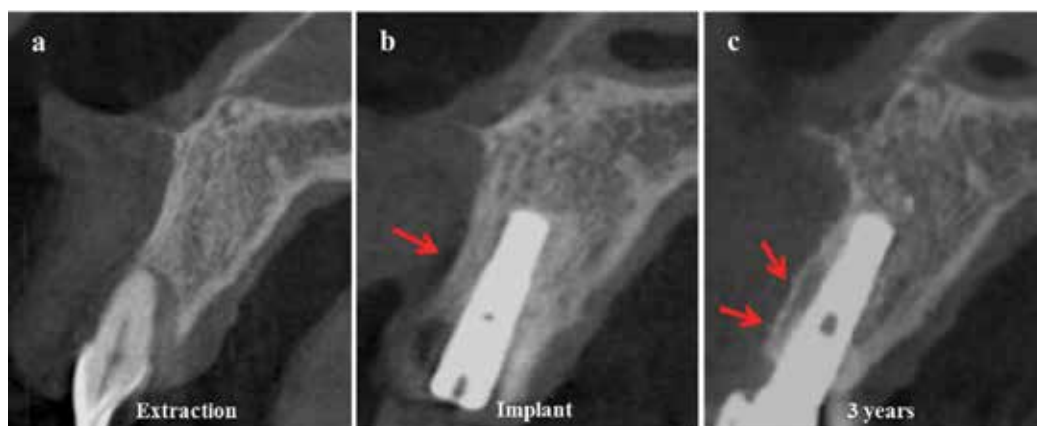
3D reconstructive image from CBCT. (a) The demineralized buccal cortical bone which was expected to be resorbed. (b) The alveolar bone surround the implant neck have been completely remodeled into a mature cortico-cancellous bone complex.
